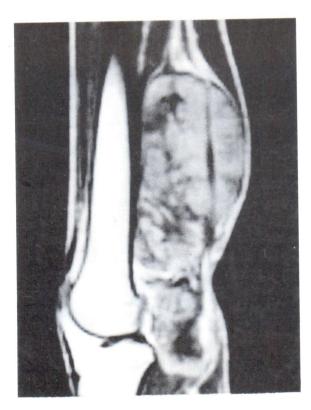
Recureent aggressive fibromatosis in the thigh in a 17 year old male. MR shows a mass in the posterior compartment which is isointense with muscle on the (a) sagittal T1-weighted (SE 580/15) image and hyperintense on (b) axial T2-weighted (SE 2900/80) image except for some low signal areas probably representing fibrous septae. It shows patchy enhancement after contrast on the (c) sagittal T1-weighted (SE 580/15). The findings suggested a malignant soft tissue tumour.
